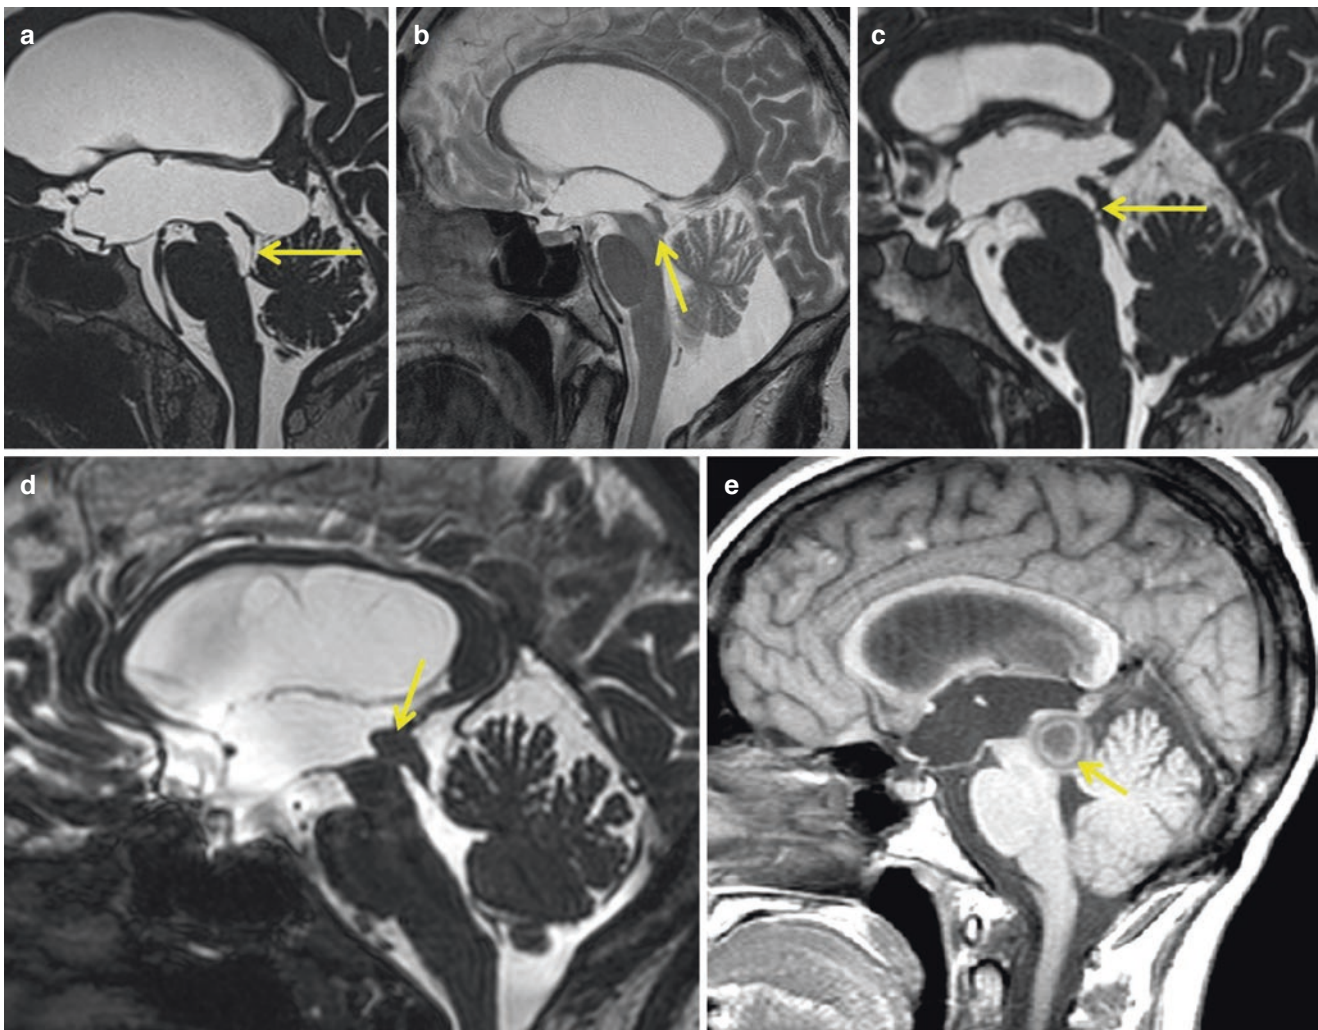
Examples of non-tumoral and tumoral aqueductal stenosis detected on midsagittal MR images. (a) Web; (b) Adhesion; (c) Forking; (d) Tectal glioma; (e) Abscess
